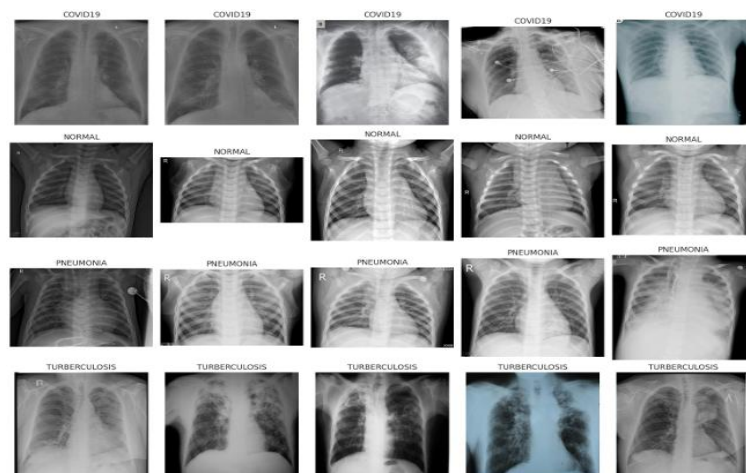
Representative radiographic samples from the dataset.
